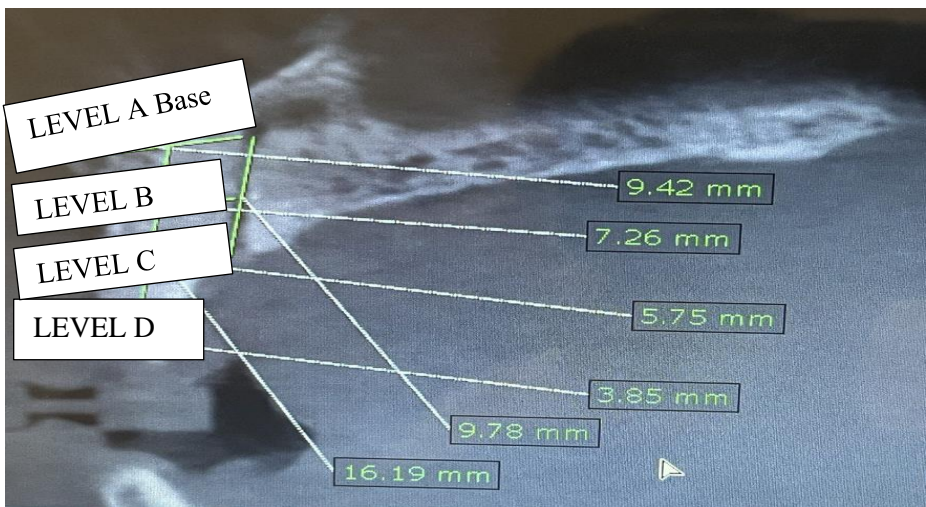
Descriptive analysis of Premaxilla levels in sagittal view of CBCT
